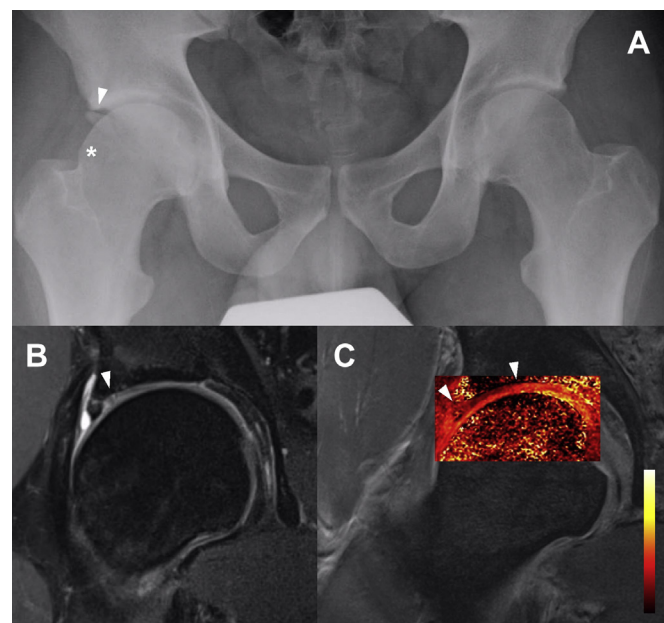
(A): Pelvic radiograph. The right hip shows signs of mixed impingement, with CAM (*) and pincer impingement (white arrowhead). There is no evidence of JSN seen on radiograph but a rim fracture is noted. (B): A morphologic MRI with indirect arthrography of the same diseased right hip, which shows labral chondral degeneration (white arrowhead). (C): A dGEMRIC scan of this hip shows fairly extensive acetabular cartilage damage as indicated by dark red and black regions in the acetabular cartilage (area between two white arrowheads).
